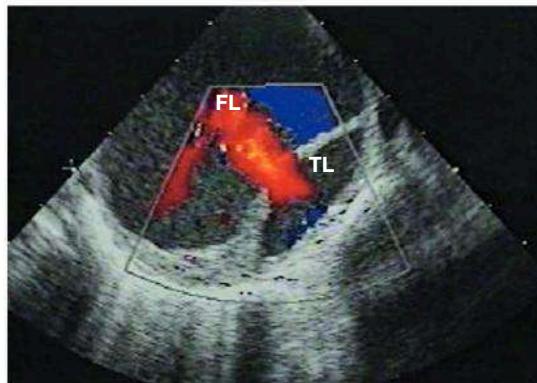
Echocardiograms from a patient with a chronic aortic dissection. Colour-flow Doppler shows flow from the larger false lumen (FL) into the true lumen (TL), characteristic of chronic disease.
